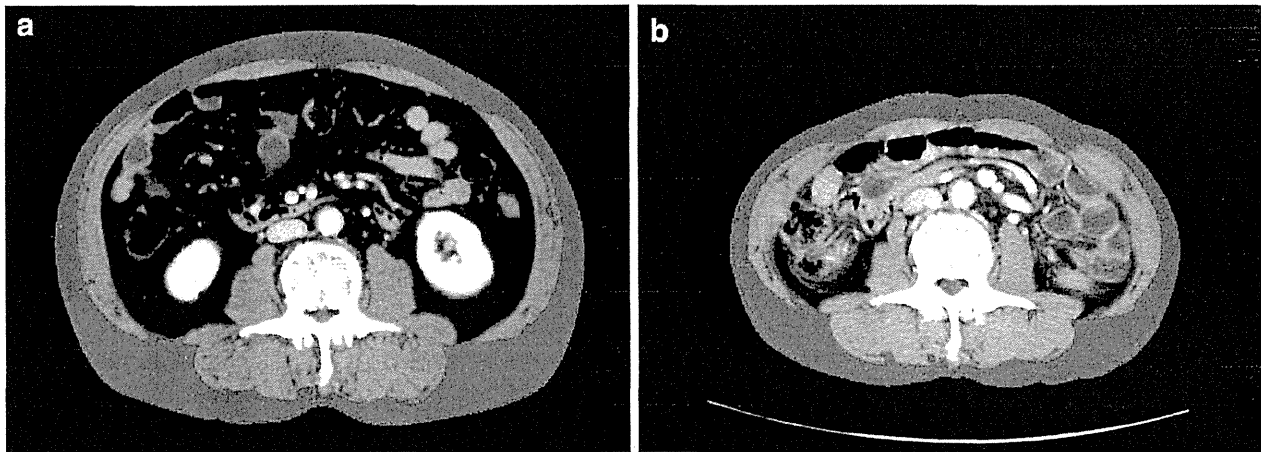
Typical transverse CT images at L3 show postoperative changes in subcutaneous and intramuscular adipose tissue (*green*). The preoperative subcutaneous and intramuscular adipose tissue area of 135 cm² (a) decreased to 89 cm² at 1 year after surgery (b)
